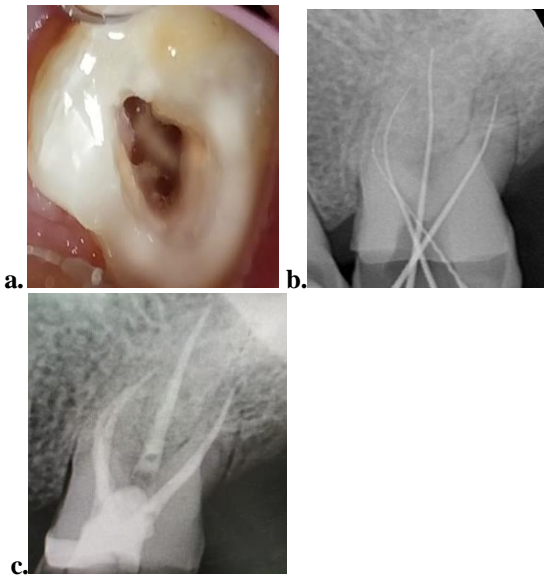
Representing canal configuration in the mesiobuccal root, type not defined a. Photograph of access cavity, b. Working length determination x-ray, c. Post-obturation x-ray
